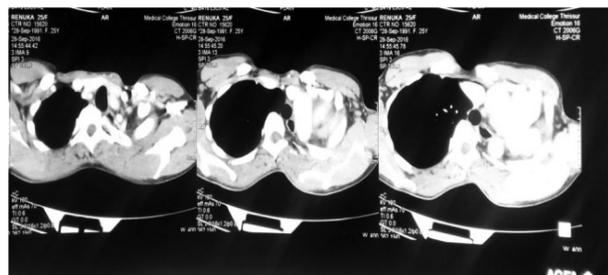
CT Thorax with contrast- absent lungs in left side, heart occupying left hemithorax
